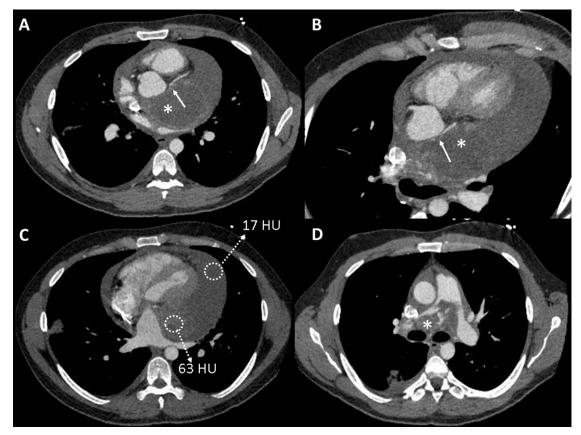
(A–D) Cardiac computed tomography. (A,B) Multiplanar computed tomographic reconstruction demonstrating severe extrinsic compression of the ostial left anterior descending coronary artery (*arrow*), by the large PA intimal sarcoma (*asterisk*). (C) PAS is located lateral to the left atrium and mitral annulus, with a mean attenuation value of 63 Hounsfield units (HU), as opposed to 17 Hounsfield units seen within the pericardial fluid, suggesting high proteinaceous content. (D) PAS invading the main PAs, resulting in severe intraluminary obstruction within the right PA (*asterisk*).
